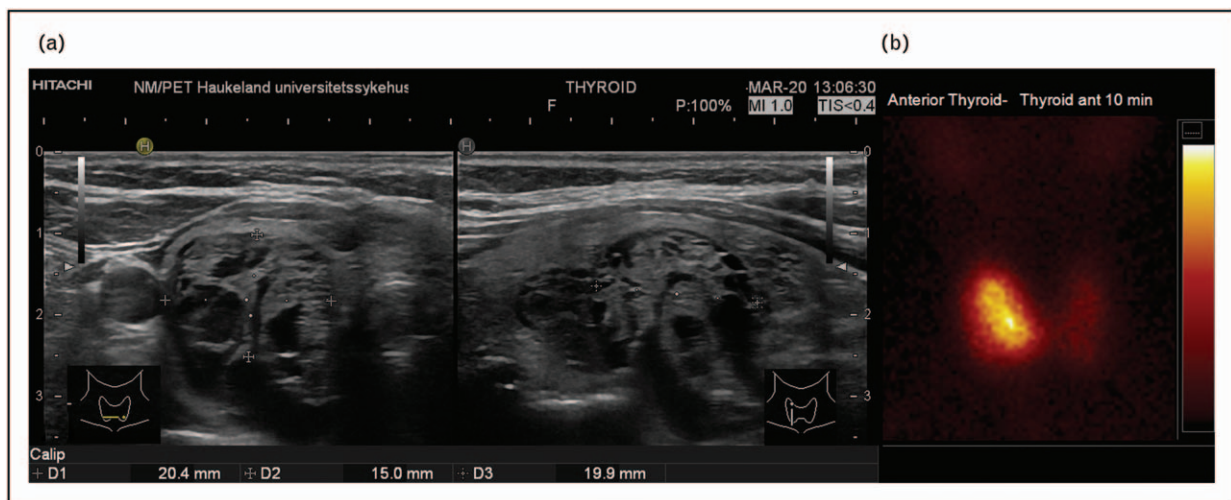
A 71-year-old woman referred for thyroid ultrasound and FNB because of a thyroid nodule detected on computed tomography. The patient's serum TSH of $0.2 \mu\text{U/ml}$ had not been considered in the referral. Thyroid ultrasound (a) revealed a conglomerate of hypoechoic nodules in the right thyroid lobe. ACR-TIRADS recommends FNB for this thyroid nodule. Scintigraphy (b) showed that the nodules were toxic, obviating the need for FNB. The patient was treated with radioiodine. FNB, fine needle biopsy. Adapted with permission from [25].
